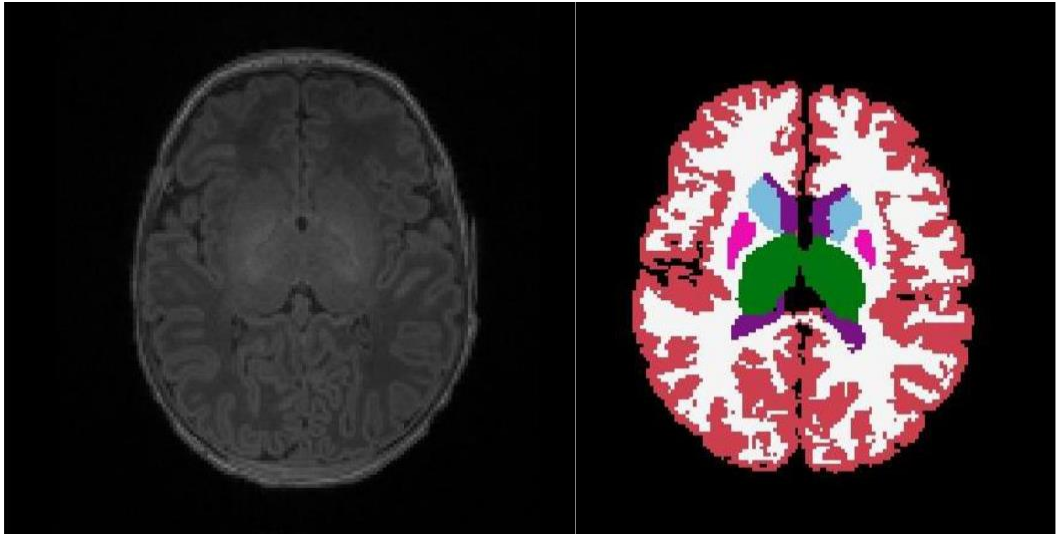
Axial view of T1-weighted Infant MRI before and after volumetric segmentation
